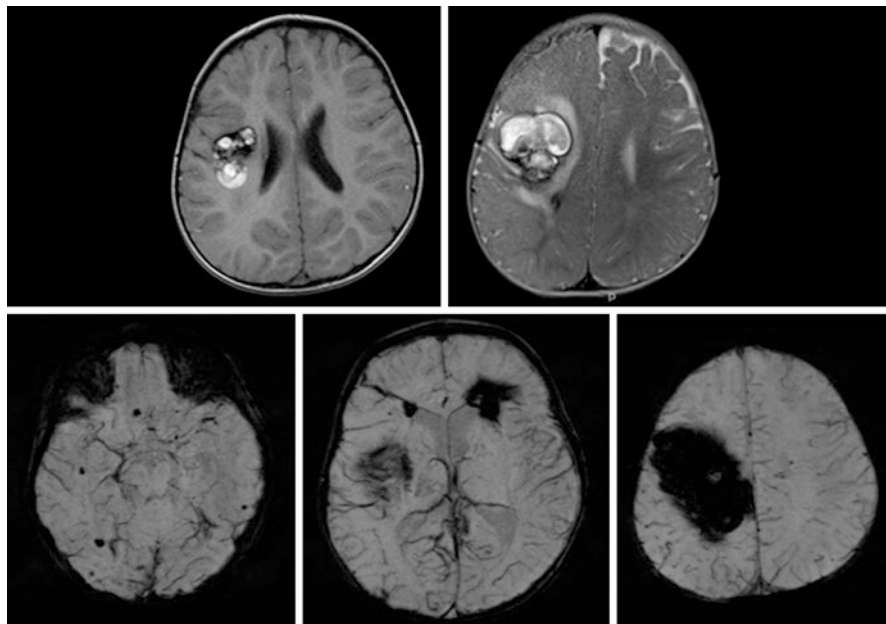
Nineteen-month-old girl with seizures and history of cerebral cavernous angiomas. Axial T1-weighted, T2-weighted, and SWI images reveal a large T1/T2-heterogeneous cavernoma within the right hemispheric white matter. The cavernoma is surrounded by a mild amount of white matter edema. On SWI multiple additional hypointense cavernomas are noted as well as a transmantle DVA in the right frontal lobe
